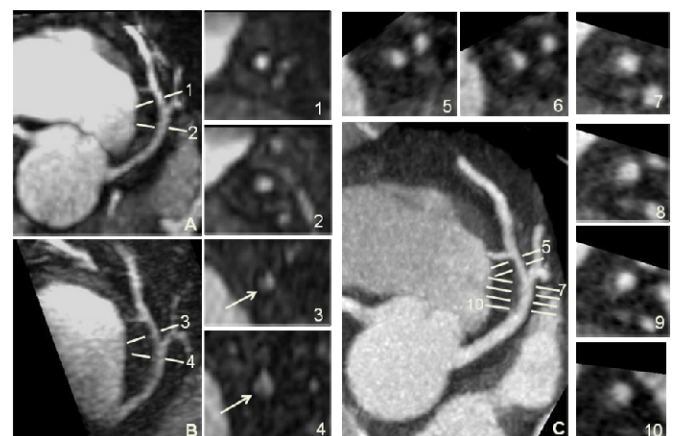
A 49 years old male patient. (A) Pre-contrast MRA showed LAD normal (no luminal stenosis and visible plaque). (B) Post-contrast MRA detected atherosclerotic plaques on cross-section views (small fig. 3-4, white arrow) with slight luminal stenosis. (C) CTA demonstrated coronary atherosclerotic non-calcified plaques on LAD.
